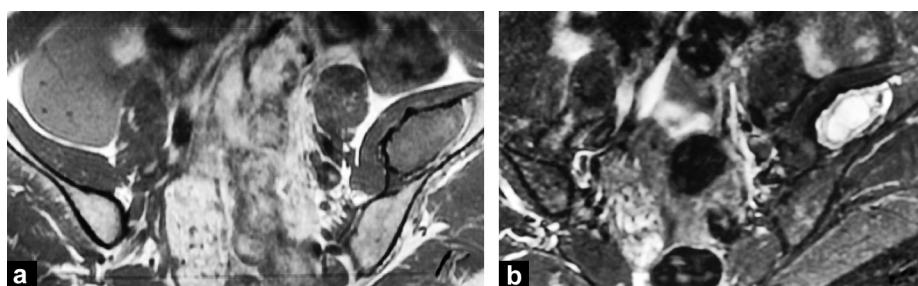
Pelvis MRI shows subperiosteal lesion of intermediate signal on T1-weighted sequence (a) and high heterogeneous signal on T2-weighted sequence (b).
